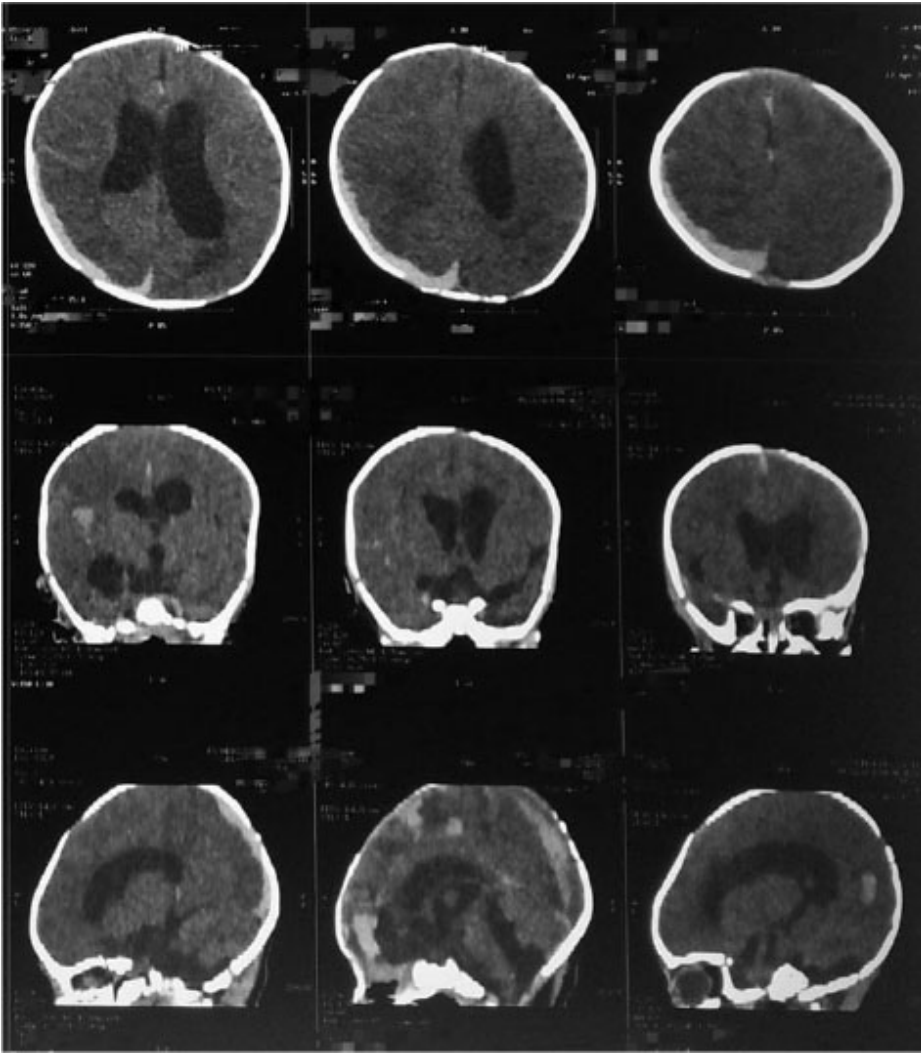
Head computed tomography scan examination.
